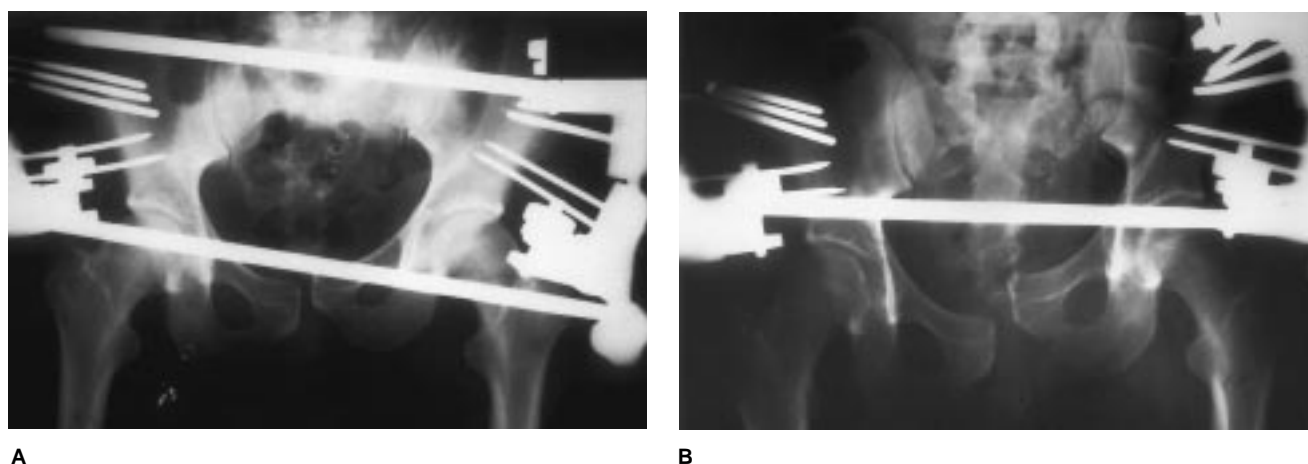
Images of a patient who sustained an unstable (type C) fracture of the hemipelvis with a fracture through the left sacrum and symphyseal disruption. A, Anteroposterior radiograph shows the posterior lesion to be adequately reduced, with some displacement at the symphysis. Fixation was with a double-cluster frame with two pins in the supra-acetabular area and three in the iliac crest, which is one of the most stable constructs. B, When the patient was allowed out of bed, there was marked displacement of the left hemipelvis through the sacrum and the symphysis, with complete loss of reduction.
